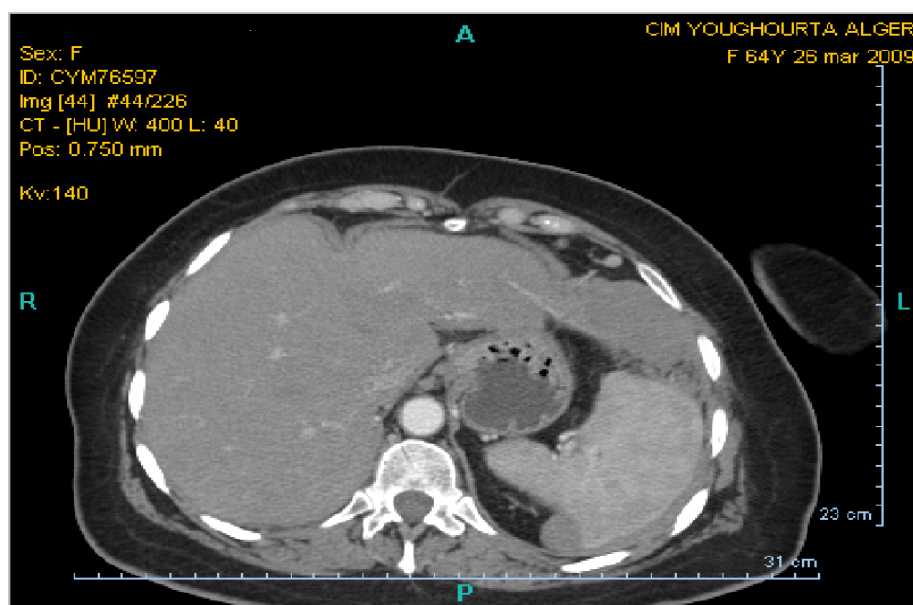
CT SCAN. Left hypochondrium with minimal lesion left in place. Two months postoperative (Case 2).
